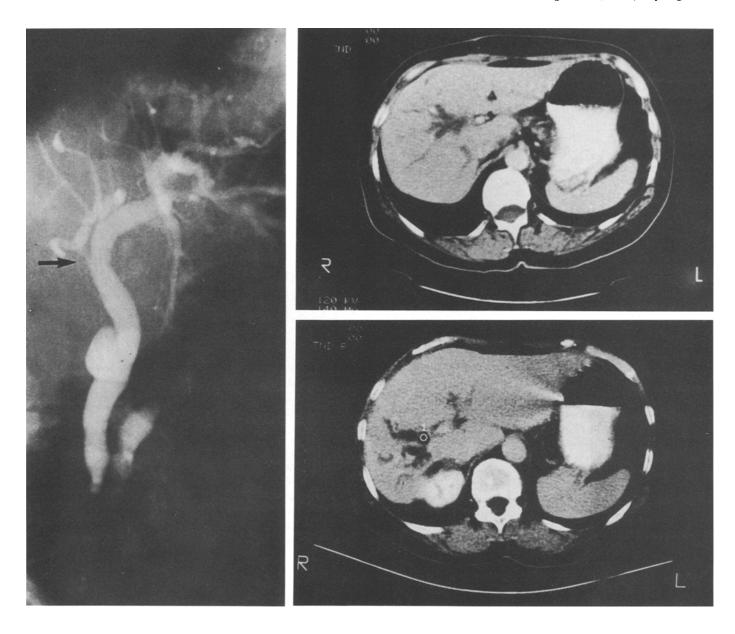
Inadvertent ligature with transection of the right duct. The patient was referred 4 weeks after cholecystectomy with abdominal pain and pathologic liver function tests of cholestatic pattern (alkaline phosphatase 1400 U/L). Left. Endoscopic cholangiography revealed complete occlusion of the right duct (arrow) without bile leakage. Top right. CT scan shows dilated bile ducts in the right hepatic lobe. Bottom right. Follow-up CT scan 3 years later shows atrophy of the right lobe with persistent bile duct dilation and hypertrophy of the left lobe. The patient was symptom-free with near-normal liver function tests (alkaline phosphatase 190-250 U/L) 5 years after operation.
